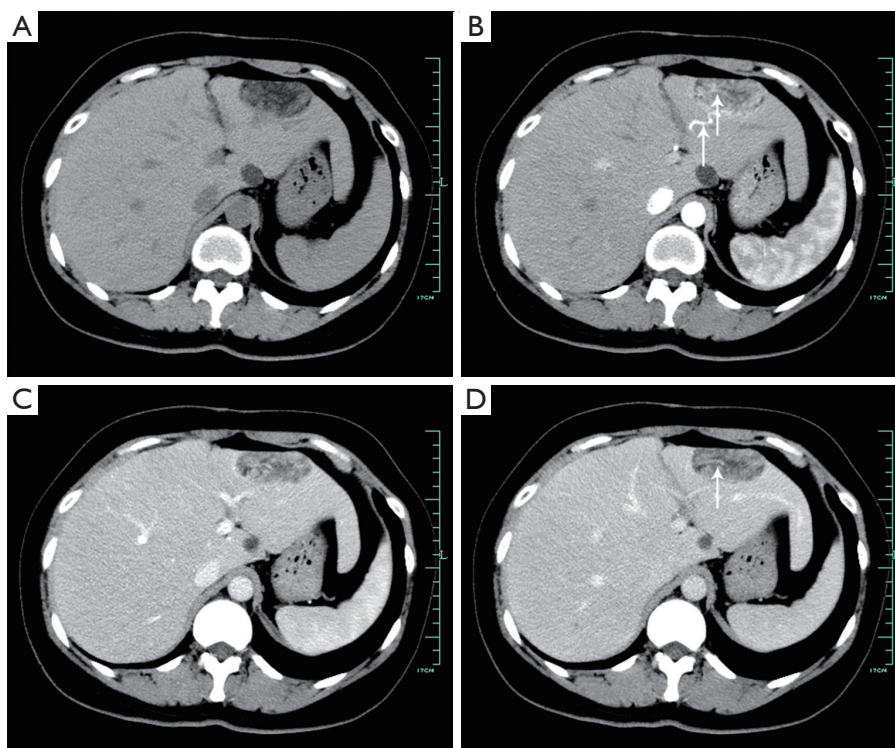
A 37-year-old female with an asymptomatic hepatic mass. (A) A plain CT scan shows a circumscribed mass with a size of 2.4 cm × 5.3 cm in the left lobe containing large amounts of fat components. (B) During the arterial phase, the mass shows heterogeneous enhancement with a supplying blood vessel and intratumoral blood vessel (arrows). (C,D) Enhancement of the mass is slightly decreased during the portal phase and delayed phase, with an intratumoral blood vessel (arrow).
